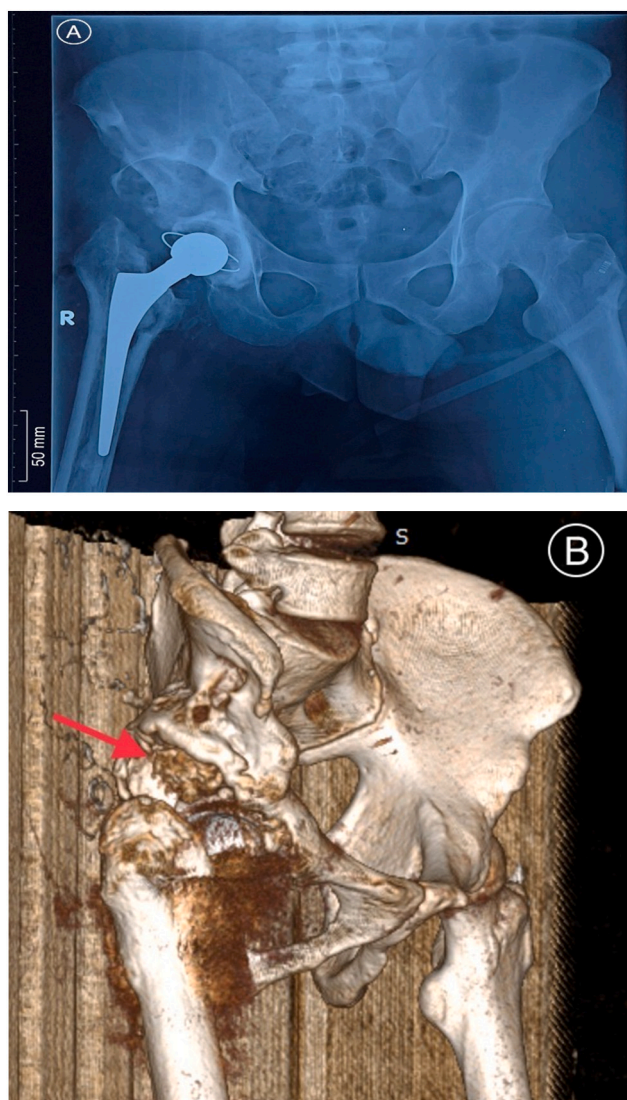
Recent Pelvic X-Ray (A), with CT-Scan that indicates the bony structure encapsulated the true acetabular (B, C).
